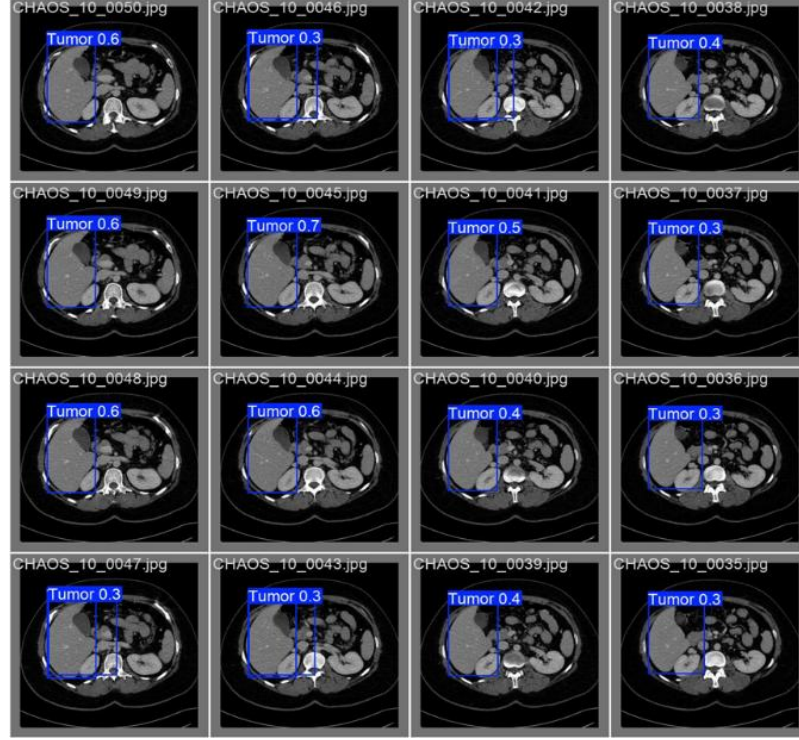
YOLOv8 detections across a montage of axial CHAOS CT slices. Predicted hepatic regions are drawn as bounding boxes with associated confidence scores.
